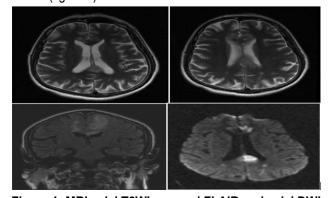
MRI axial T2WI, coronal FLAIR and axial DWI demonstrate hyperintense signals in genu and splenium of corpus callosum extending subcortical regions (best seen on FLAIR image) showing diffusion restriction.
